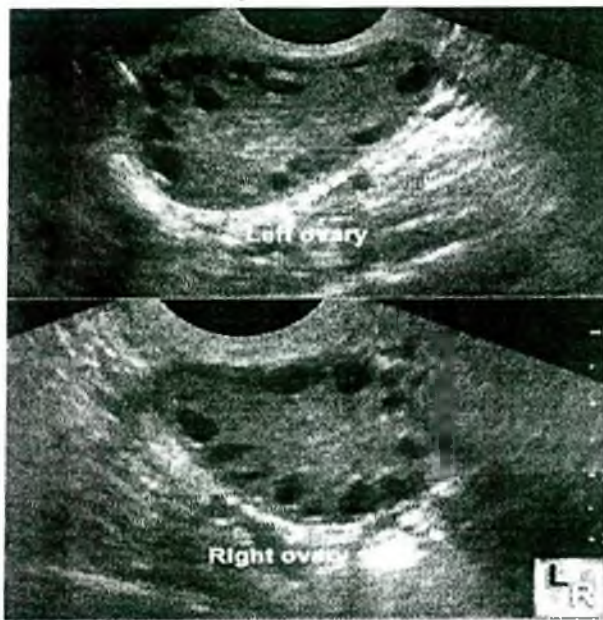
Sonographic criteria of polycystic ovaries
